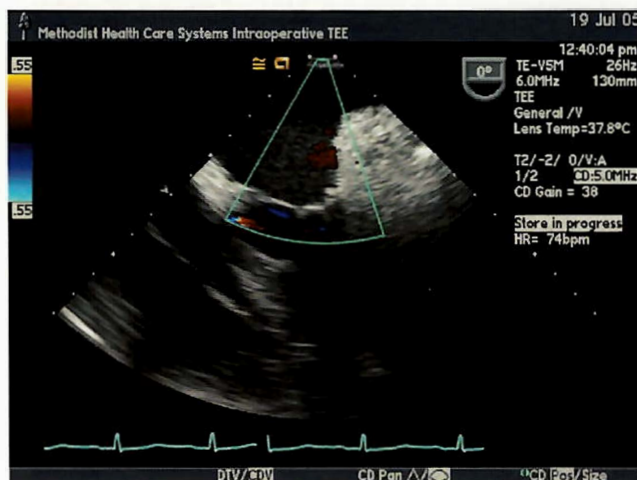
Midesophageal four-chamber view with color flow Doppler during systole demonstrating resolution of mitral regurgitation
